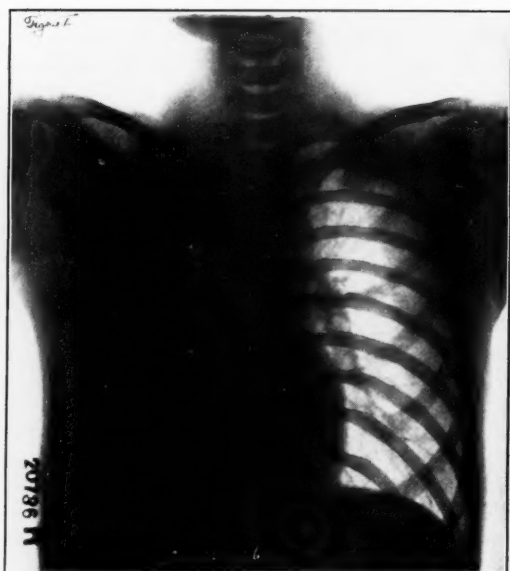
Roentgenogram showing postoperative atelectasis of the right lung. A patient of Dr. Walter Estelle Lee at the Germantown Hospital, Philadelphia. Film by Dr. Thomas P. Loughery. The heart is displaced well into the right chest and there is evidence of atelectasis of marked degree in the right lower and middle lobes. Film was made just prior to bronchoscopic aspiration of the thick, tenacious secretion from the bronchi.
